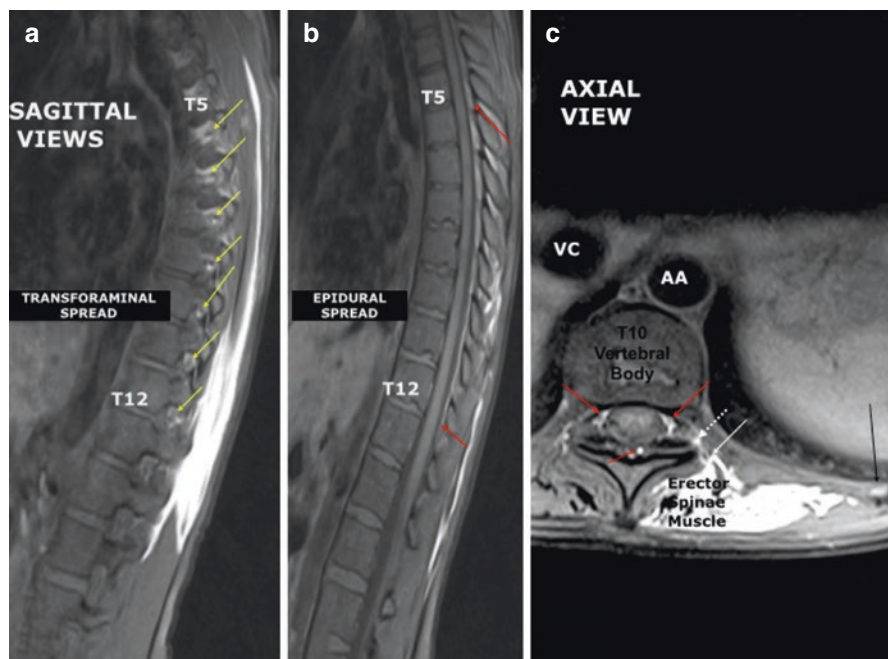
Magnetic resonance imaging with gadolinium contrast added to bupivacaine erector spinae plane block (30 mL total volume) injected at the left T10 level. (a) Sagittal view at the level of the intervertebral foraminae showing transforaminal spread of the gadolinium from T5 to T12 of the left side (yellow arrows). (b) Sagittal view of the spinal canal depicting epidural spread (red arrows) of the contrast from T5 to T12. (c) Axial view at the T12 level demonstrating the spread of gadolinium from the erector spinae plane through paravertebral space (dashed white arrow) transiting the intervertebral foramina (yellow arrow) to spread circumferentially (red arrows) within the epidural space. Some venous uptake of gadolinium is also noted. (Modified, with permission, from the original unpublished image in the Philip Peng Educational Series collection (Toronto, ON, Canada))
